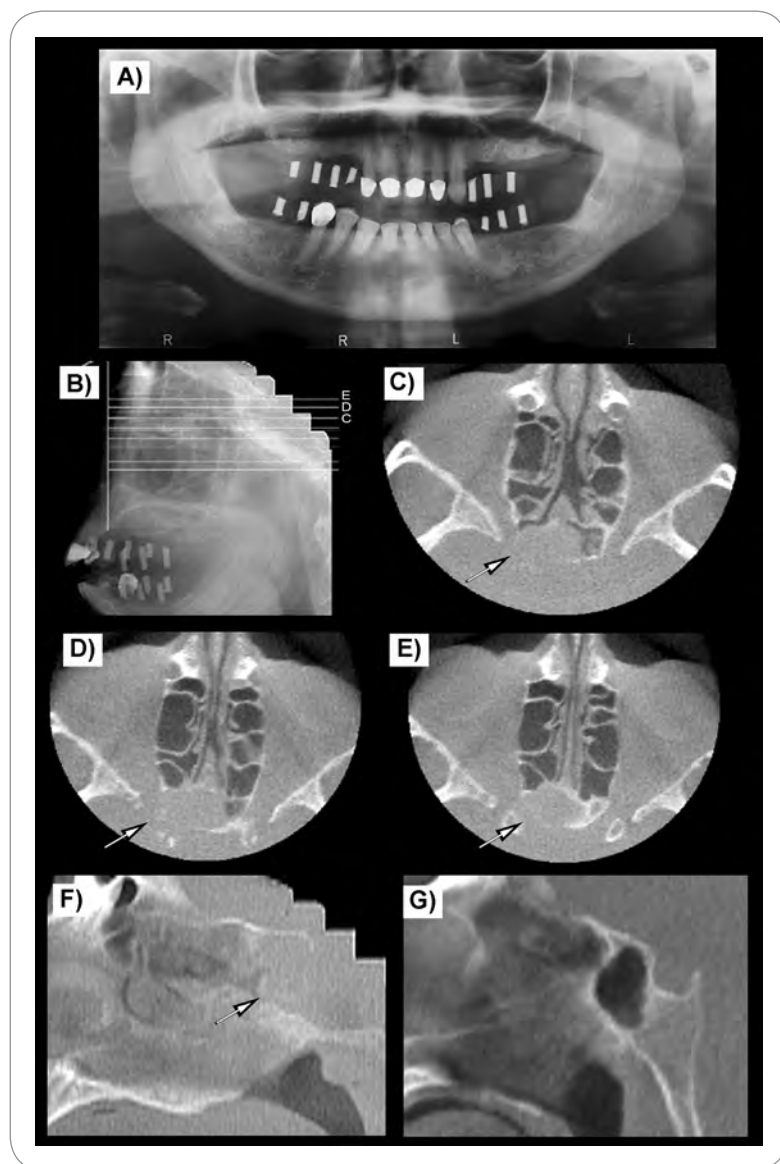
(A) Conventional panoramic radiograph of patient B prior to implant placement. Twelve radiopaque markers at the areas of prospective implants are in place. The facial structures are unremarkable. (B) Detail of scout view from CBCT. The radiopaque markers are seen at the area of the jaws. The position of axial slices through the midface and base of the skull area is marked. (C, D and E) Three representative axial slices through the base of the skull. Note opacification of the sphenoid sinus and destruction of the sphenoid sinus walls and floor of the sella turcica (arrows). (F) Sagittal slice at the midline, through the skull base. Destruction of the sella turcica and complete opacification of the sphenoid sinus are seen (arrow). (G) Sagittal slice at the midline, through the skull base of a normal individual is provided for comparison with (F). The lesion in patient B was subsequently determined to be a pituitary gland tumor.
